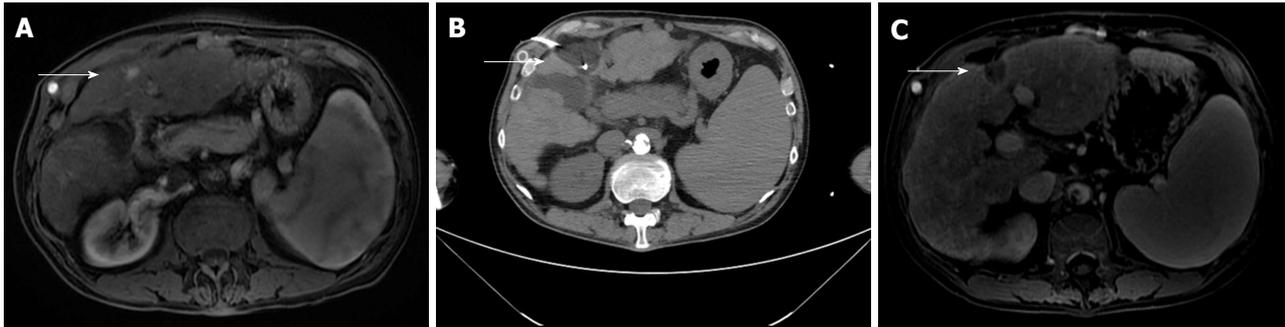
Sixty-one-year-old with a history of alcohol abuse and cirrhosis. A: MRI demonstrates a 13 mm HCC in the left lobe; B: Two cryoablation probes covering the lesion; C: Post contrast follow up MRI shows capsular retraction at the site of the cryoablation and no residual tumor. MRI: Magnetic resonance imaging; HCC: Hepatocellular carcinoma.
